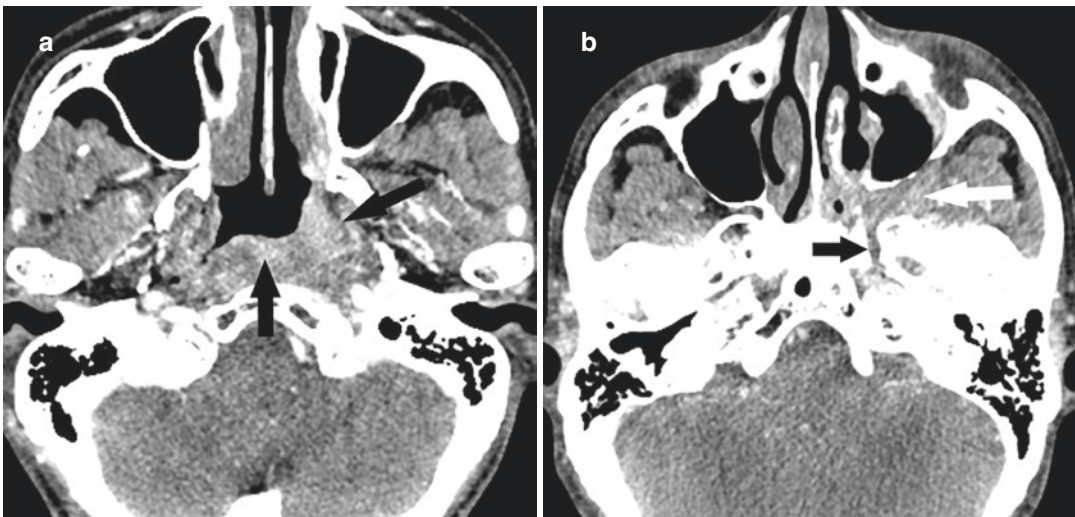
Nasopharyngeal carcinoma. (a) Axial contrast-enhanced CT image shows infiltrative enhancing soft tissue at the posterior wall and left lateral wall of the nasopharynx (black arrows). Biopsy showed nonkeratinizing
